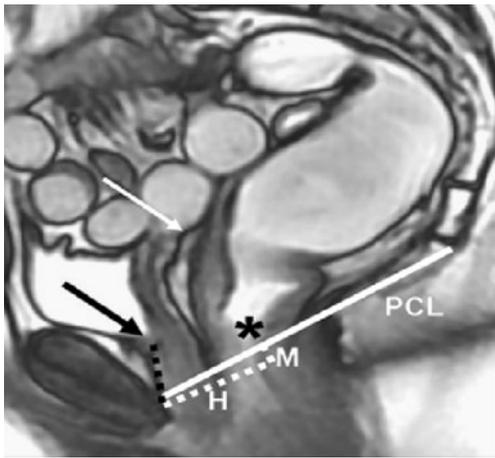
Sagittal MRI image obtained at rest in a 50-year-old normal volunteer woman. The PCL is drawn from the inferior border of the pubic symphysis to the last coccygeal joint. The *H line* is drawn from the inferior border of the pubic symphysis to the posterior wall of the rectum at the level of the anorectal junction. The *M line* is drawn perpendicularly from the PCL to the most posterior aspect of the H line. Images show normal positions of the bladder base (*black arrow*), the vaginal vault (*white arrow*), and anorectal junction (*asterisk*) with respect to the PCL (with permission from Colaiacomo et al. [72])
